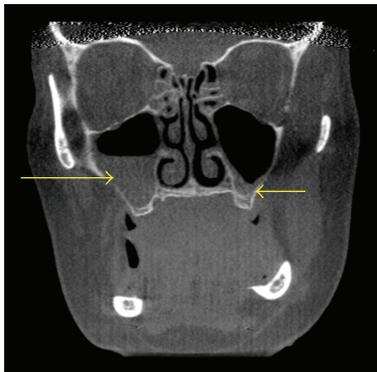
Coronal CT scan demonstrating bilateral maxillary sinusitis (arrows). The degree of sinus inflammation is more prominent in the right sinus. Concha bullosa or nasal septal deviation are not noted.
